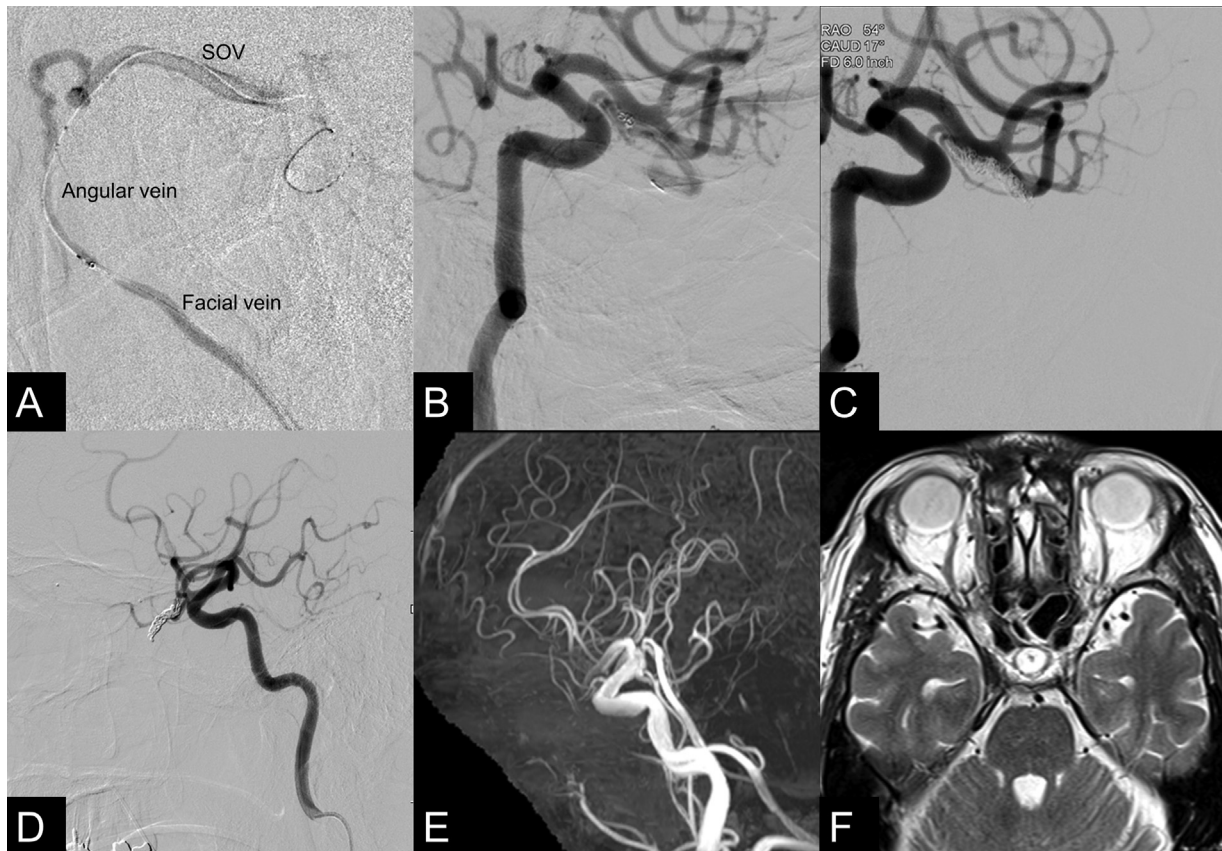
Intra- and postoperative imaging. (A–D) Lateral (A,D) and right anterior oblique view (B,C) of the intraoperative cerebral angiography. A microcatheter was placed just distal to the shunt point via the facial, angular, and superior ophthalmic veins (SOV) (A). Coil embolization was started just distal to the shunt point (B), and a total of six coils was deployed (C). The shunt blood flow had disappeared after embolization (D). (E,F) Postoperative imaging at 3 months after the procedure. The flow void had disappeared on magnetic resonance (MR) angiography (E), and the SOV was thin on the coronal T2-weighted MR image (F).
